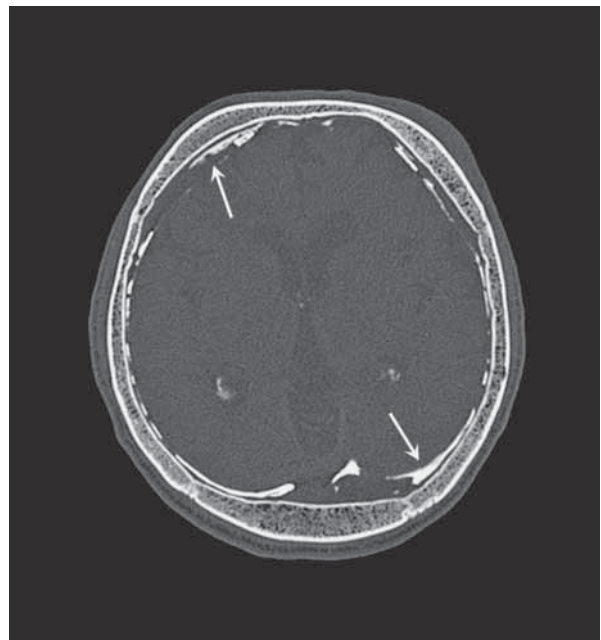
CT scan – bone window: calcifications were confirmed on bone window, where the density of hyperdense areas corresponded to bone (≈ 1900 Hounsfield units) (arrows).
